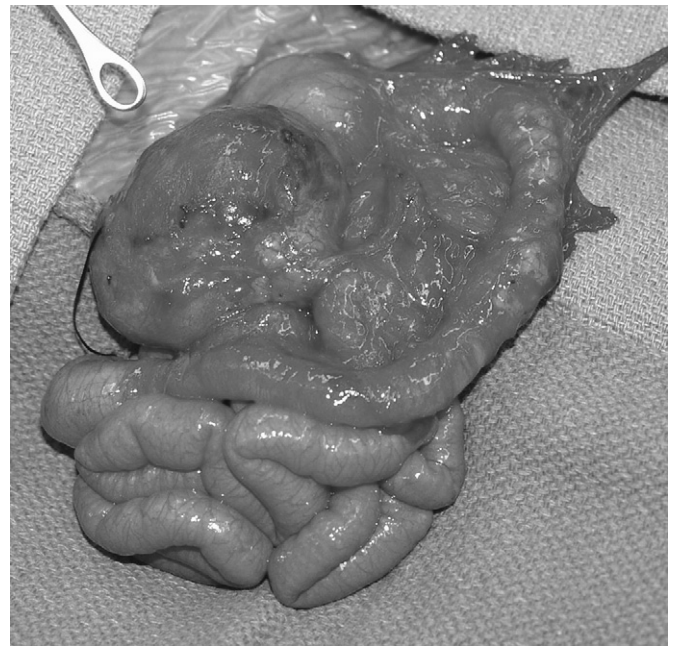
This cystic mass occurred in an infant with vomiting and gastric outlet obstruction and was completely resected. The computed tomography scan of this giant duodenal duplication is shown in Figure 90-2. (Courtesy Dr. Aimen Shaaban.)
